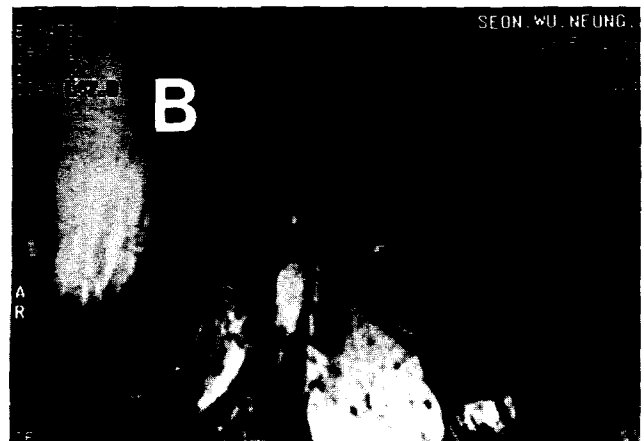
Amorphous disc configuration in closed (A) & open (B) mouth seen by T1-weighted sagittal MR image of anterior displacement without reduction of the temporomandibular joint in 33-years female.
